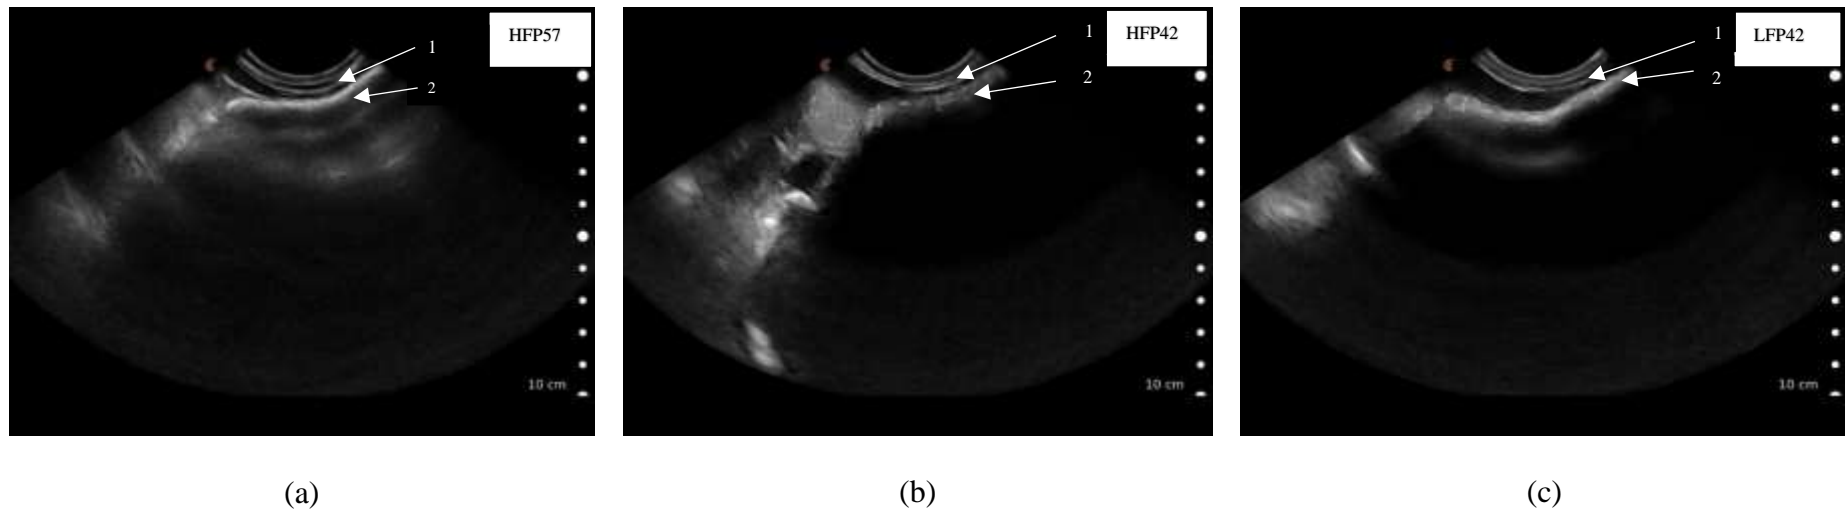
Ultrasound scanned images showing rumen wall thickness captured caudal to the last rib by placing the Clarius ultrasound scanner (3.0-7.0 MHz) parallel to the last ribs of seven weeks (49 ± 1.2 days) old lambs ((a) HFP57, high fibre concentrate pellet and milk feeding to 57 days of age; (b) HFP42, high fibre concentrate pellet and weaning at 42 days of age; (c) LFP42, low fibre concentrate pellet and weaning at 42 days of age) laying on its right side, 1. Abdominal wall, 2. Rumen wall.
